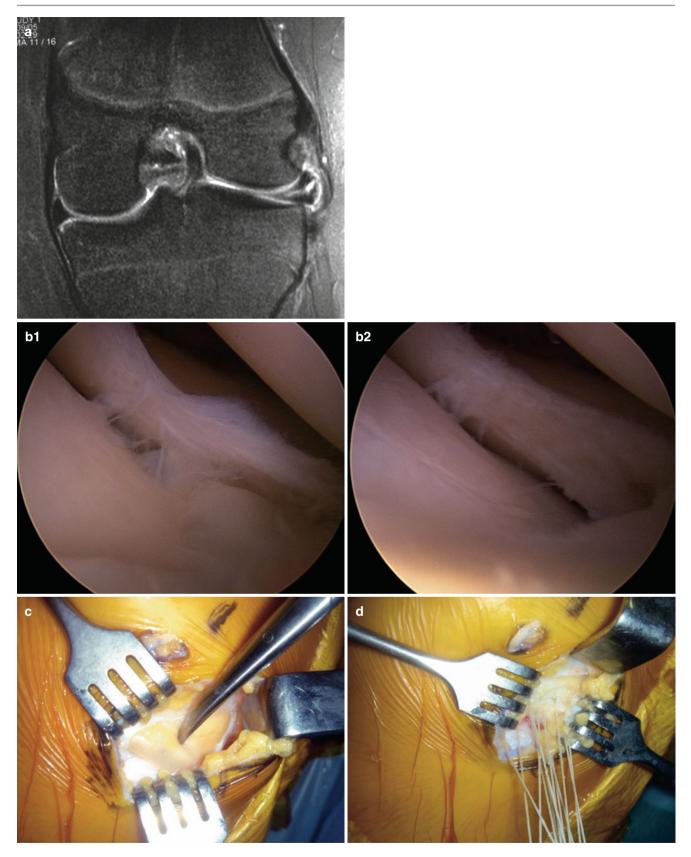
Meniscal cyst of the lateral meniscus. (a) Preoperative MRI. (b1, b2) Arthroscopic views. (c) Cyst resection using a direct open approach. (d) Vertical sutures to close the connection to the joint
